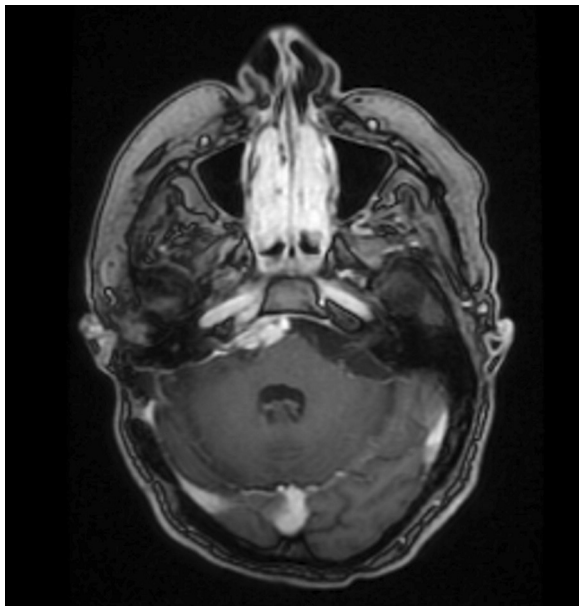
MRI image 18 years after surgery, 7 years after radiosurgery. Axial T1-weighted image with gadolinium and fat suppression. A residual right petroclival meningioma is observed, which obliterates Meckel's Cave. Surgical changes in the right retromastoid location can be observed. MRI: magnetic resonance imaging.
